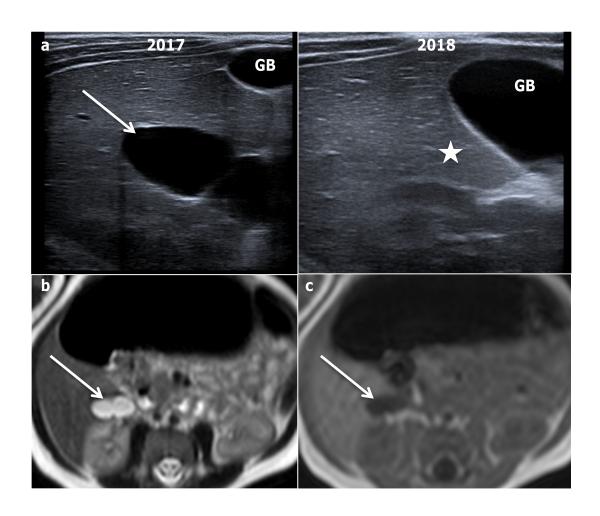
Spontaneous disappearance of a hepatic lymphatic malformation in 5-year-old male patient. (a) Ultrasonography shows biloculated homogeneous cyst (arrow) that has vanished one year later (star). It displays fluid signal (arrows) at axial T2-weighted (b) and T1-weighted magnetic resonance imaging (c).
